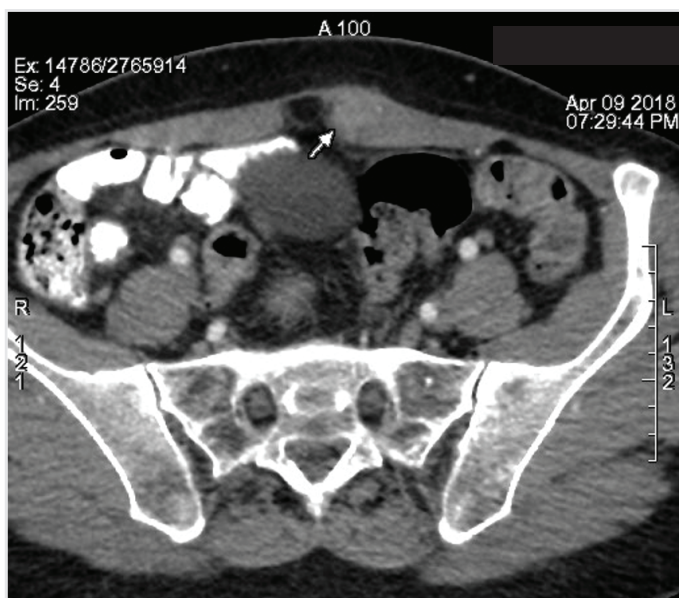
Endometrial mass on computed tomography scan
